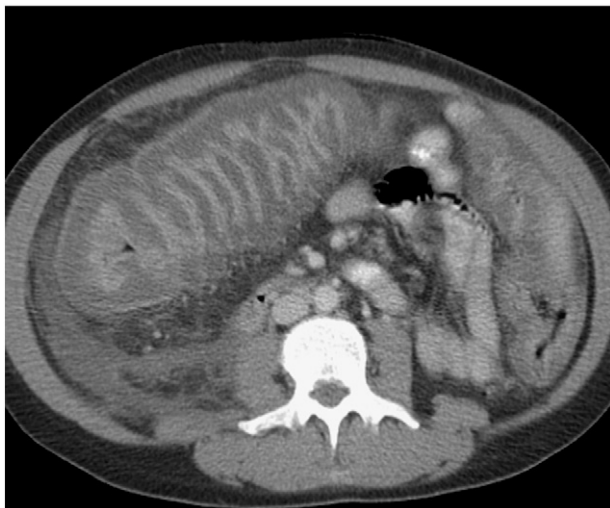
Abdominal computed tomogram of a patient with significant colonic distention, bowel wall thickening and severe CDAD (case #1).
